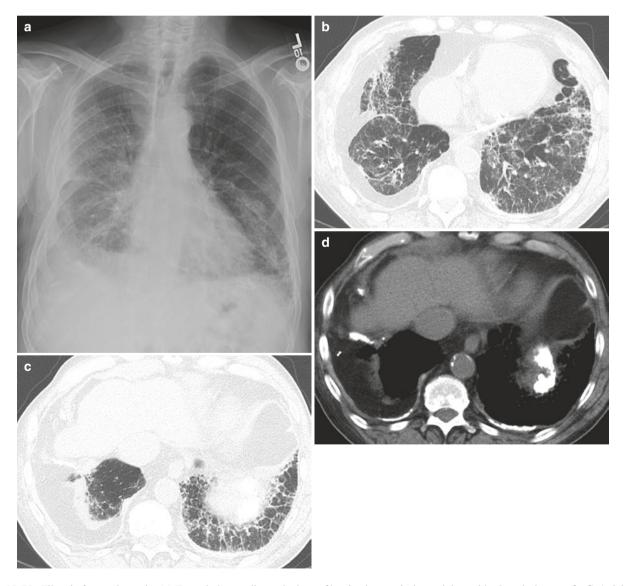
Fibrosis from asbestosis. (a) Frontal chest radiograph shows fibrotic changes in lower lobes with pleural plaques. (b–d) Axial CT images show fibrotic lung disease, pleural plaques, and extraparenchymal fat retraction
